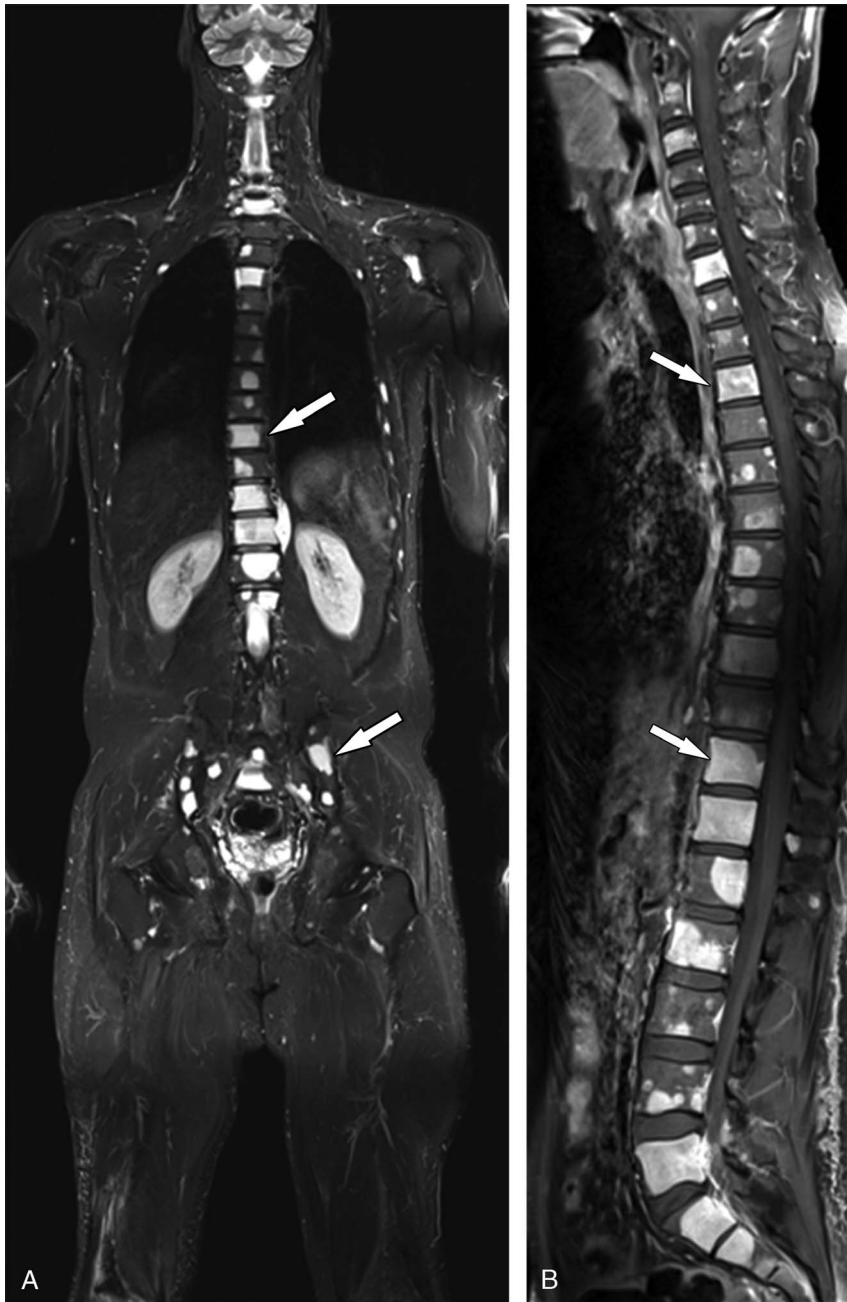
A 72-year-old man with a history of myxoid liposarcoma. A, Coronal STIR 3.0-T whole-body MRI scan shows multiple liposarcoma osseous metastases (arrows) of the pelvis and spine. B, Sagittal contrast-enhanced fat-suppressed T1-weighted 3.0-T whole-body MRI scan shows multiple enhancing liposarcoma osseous metastases (arrows) of the spine. The MRI scans were obtained with a commercial 3.0-T MRI system (slew rate, 200 T/m/s; gradient strength, 45 mT/m) using body matrix surface and spine coil arrays. Case courtesy of Prof Dr Marius Horger, Eberhardt Karls University, Tübingen, Germany.
